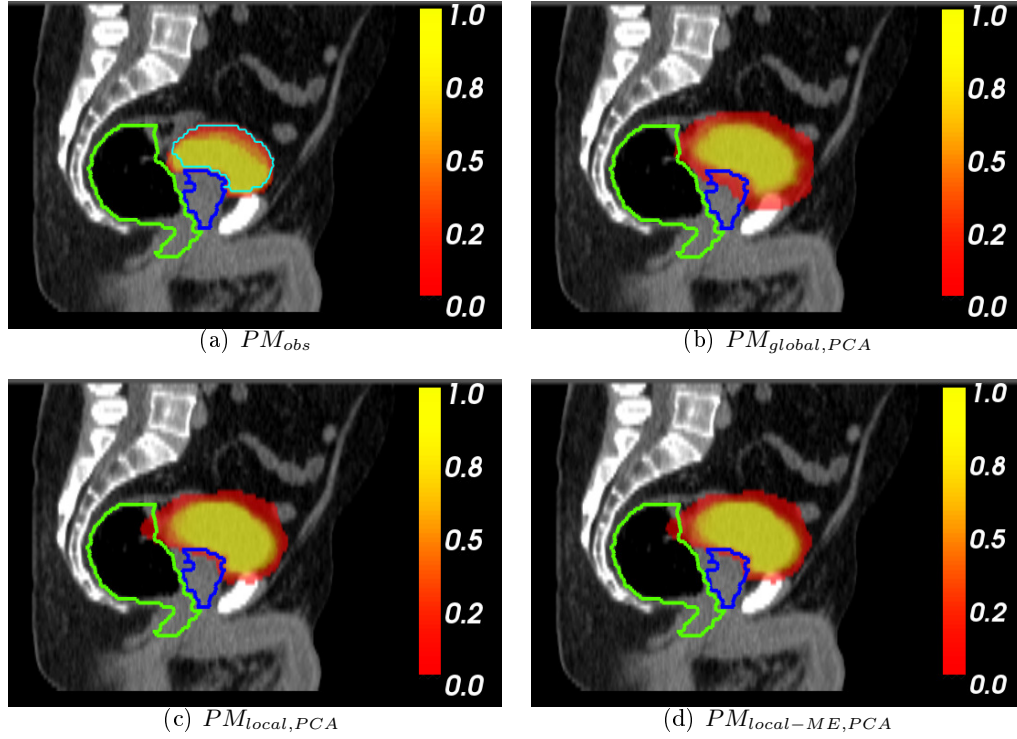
3D sagittal views of PMs obtained for one patient in the training database as an out-of-sample patient. Segmented prostate (blue) and rectum (green) at the planning CT scan are overlaid. Top left figure also depicts the segmented bladder (cyan) at the planning CT.
